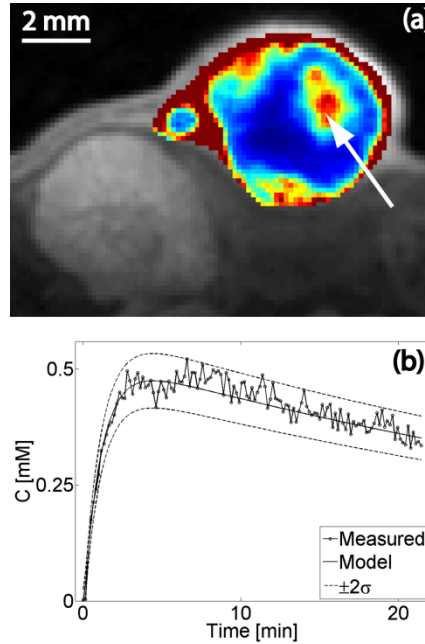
(a) Overlay of K^{trans} map on a contrast-enhanced T1-weighted image from a central slice in the tumor. (b) Time-varying contrast agent concentration in a single pixel (arrow in panel (a)). The predicted curve obtained by solving Eqn. 23 and the uncertainty estimated by Eqn. 26 are superimposed on the measured concentration curve.
